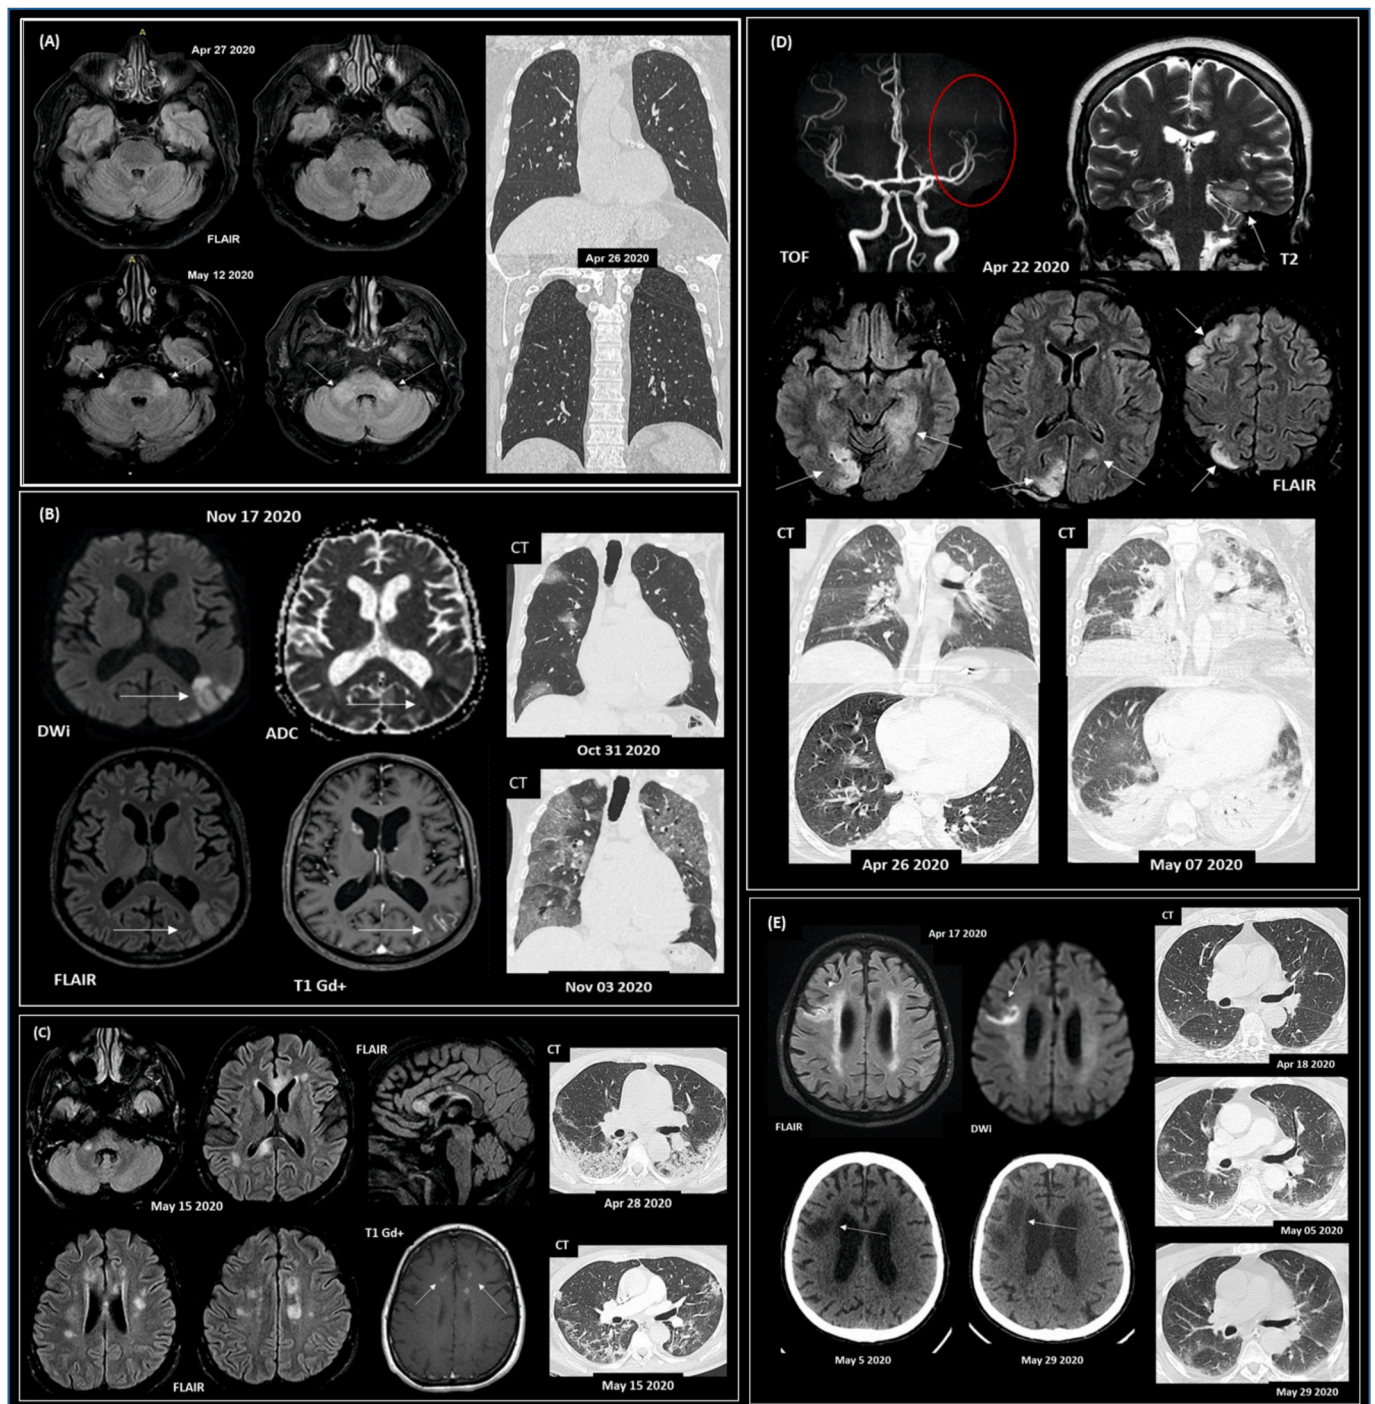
Representative paired neuroimaging and chest CT findings from COVID-19 patients presenting neurological symptoms. (A) Subject #16 (65 y/o; male) with encephalitis and a positive result for SARS-CoV-2 RT-qPCR in the CSF screening. Initial symptoms of fever and vomiting, evolving with drowsiness, ataxia, acute diplopia and convergent strabismus. No signs of viral pneumonia were detected on the CT scan. Case previously reported (Freitas et al., 2021). (B) Subject #25 (83 y/o; male; deceased) with acute CNS ischemic lesions (vasculitis); viral pneumonia, fever, respiratory distress, and rhabdomyolysis. Coronal chest CT images (lung window) show multiple areas of round ground-glass opacities, mainly on the right lung, with increasing extent after three days. (C) Subject #14 (50 y/o; female) presented acute demyelinating brain lesions and COVID-19 pneumonia. Axial CT images show areas of consolidation distributed predominantly at peripheral and posterior areas of the lower lobes and improvement in lung infiltrates after 17 days. (D) Subject #27 (29 y/o; female; deceased) with a previous diagnosis of Systemic Lupus Erythematosus, presenting CNS vasculitis; refractory epileptic status; and viral pneumonia. Evolution to progressive global systemic failure. Chest CT shows mild round ground-glass opacity on the middle lobe and upper right lung. Eleven days later, abnormalities increased with diffuse consolidation, mainly in the lower lobes. (E) Subject #23 (78 y/o; male; deceased) presented a subacute ischemic stroke with an altered level of consciousness, seizures, and coma; viral pneumonia. Axial CT images show no lung parenchymal findings consistent with viral pneumonia that progresses to mild patchy ground-glass opacity in the lungs' periphery 17 days after. Lung abnormalities are almost entirely resolved after 41 days. Subjects (B–E) with positive RT-qPCR for SARS-CoV-2 in the nasopharyngeal swab. Abbreviations: FLAIR, DWI, ADC, T1, T1 Gd+, T2 refer to MRI sequences, and Gd + represents venous contrast. Time of flight (TOF) arterial angiographic MRI sequence.
